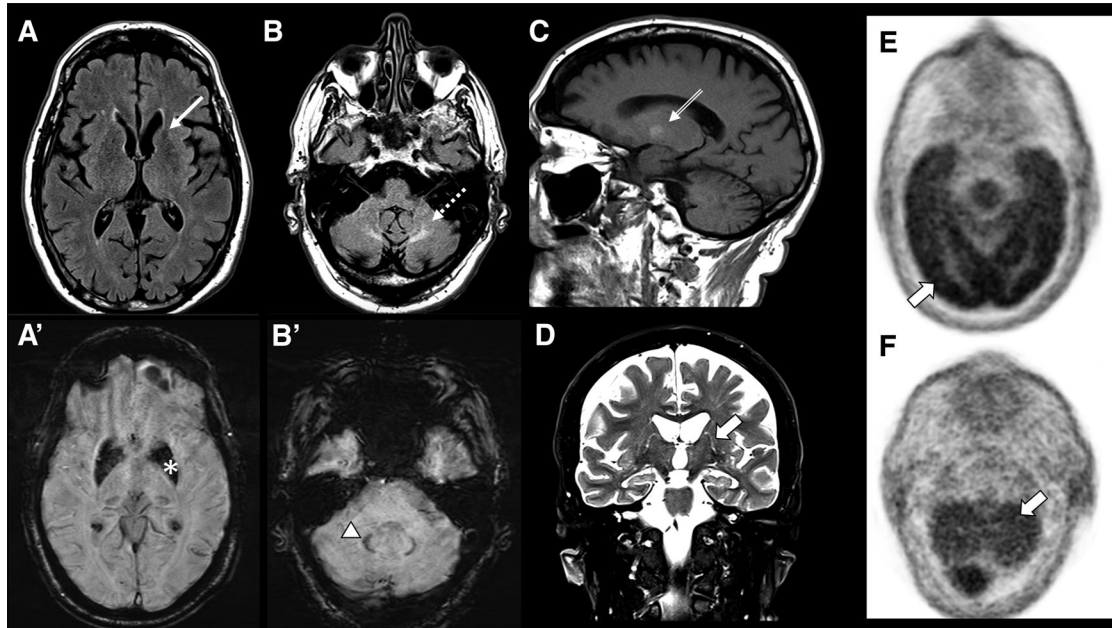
Magnetic resonance imaging in Erdheim-Chester. Fluid-attenuated inversion recovery (A,B) and gradient-echo (A',B'): striatal (thin arrow) and cerebellar (dashed arrow) atrophy and caudate, pallidus, (*) and dentate ferromagnetic deposition. T1 hyperintense pallidus (double-headed arrow; C) and T2 serpiginous images from ependyma to diencephalon (thick arrow; D).¹ Fluorodeoxyglucose-positron emission tomography (E,F): preserved cortex versus cerebellar diaschisis.
